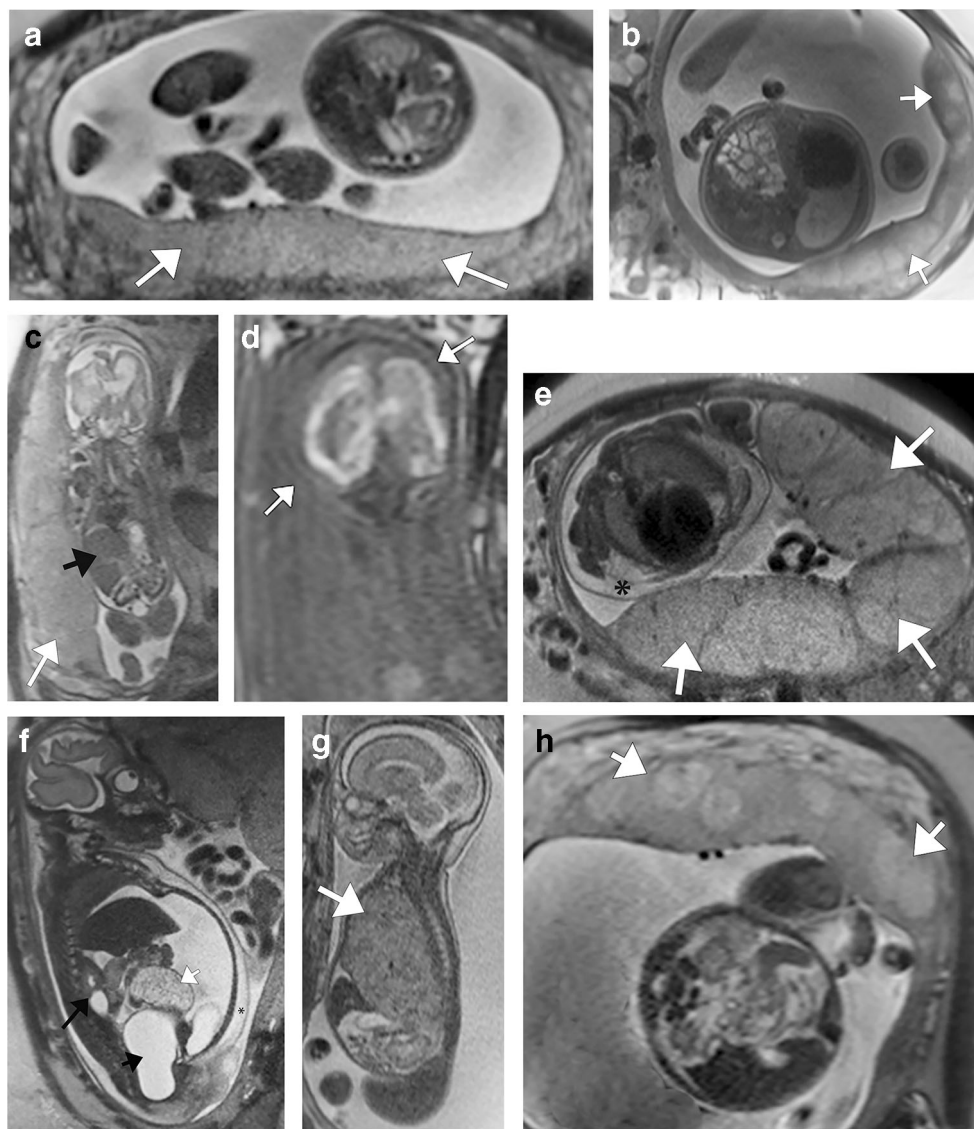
Normal and abnormal appearance of the placenta. a, b Single-shot turbo spin-echo (SSTSE) MR images of the maternal pelvis show the normal appearance of the placenta in 22-week (a) and 34-week (b) fetuses. Note the homogeneity of the placenta in the second trimester, becoming more heterogeneous and with more distinct cotyledons or placentofetal units during the third trimester. c, d Coronal SSTSE images in a 21-week fetus show abnormally thickened placenta (*white arrow* in c; compare with a). The fetus also presented with hepatomegaly (*black arrow* in c), ascites and marked hemorrhagic and destructive changes in the brain, best seen in the coronal T1-weighted image (d). The constellation of findings was thought to be from an infectious etiology. e, f Axial (e) and sagittal (f) SSTSE MR images in a 29-week
